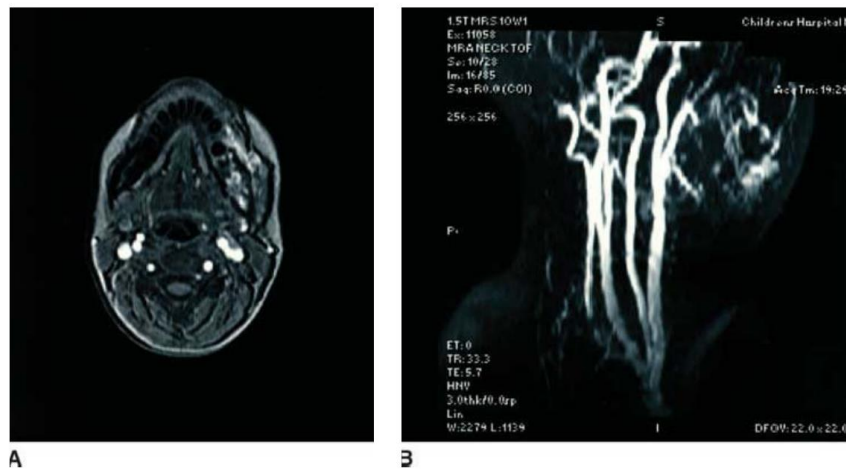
A: MRI and (B) MRA of the neck demonstrating an AVM of the left mandible.
